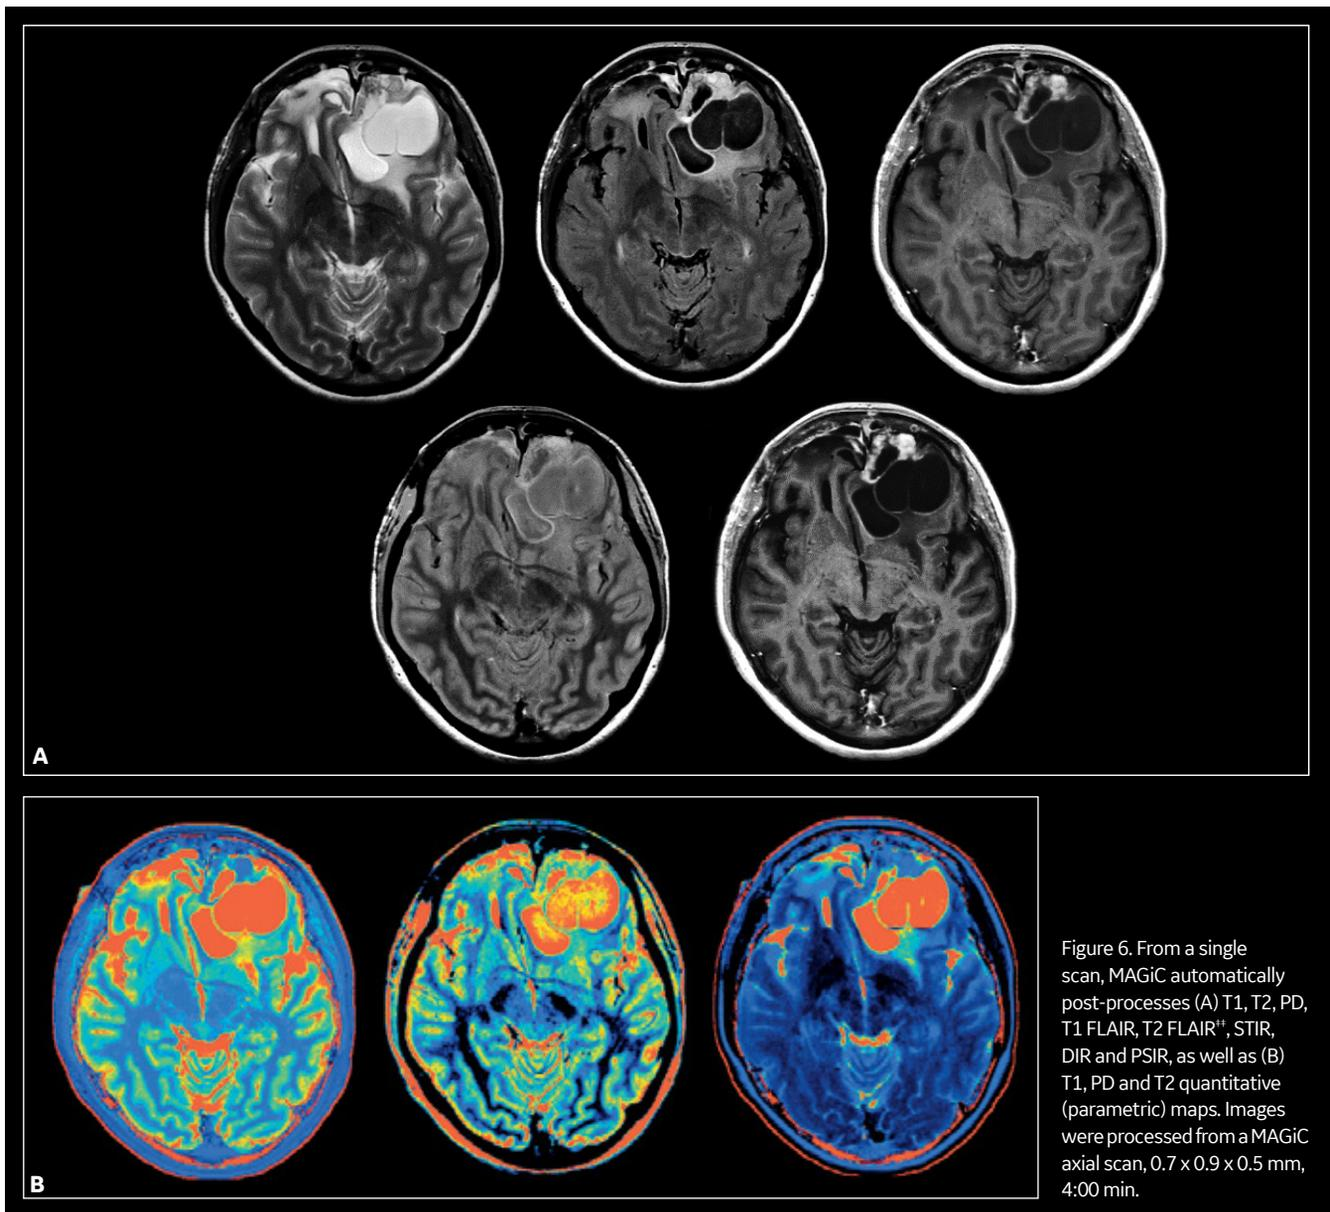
From a single scan, MAGiC automatically post-processes (A) T1, T2, PD, T1 FLAIR, T2 FLAIR<sup>††</sup>, STIR, DIR and PSIR, as well as (B) T1, PD and T2 quantitative (parametric) maps. Images were processed from a MAGiC axial scan, 0.7 x 0.9 x 0.5 mm, 4:00 min.
